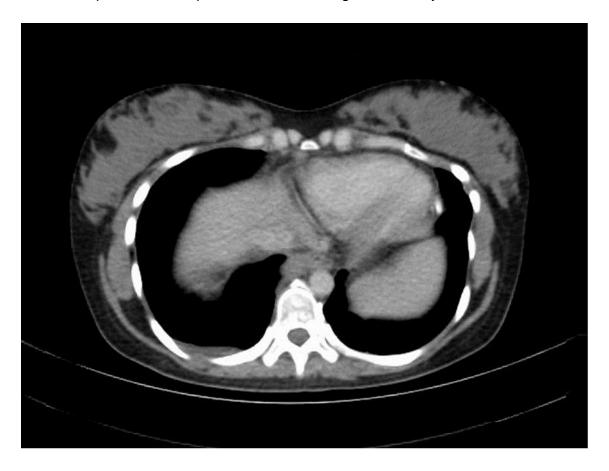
Axial contrast-enhanced CT in the portal venous phase [165].
